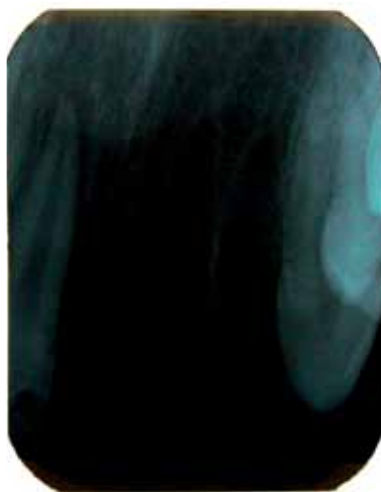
Radiograph of avulsion site confirming no other hard-tissue injuries.
